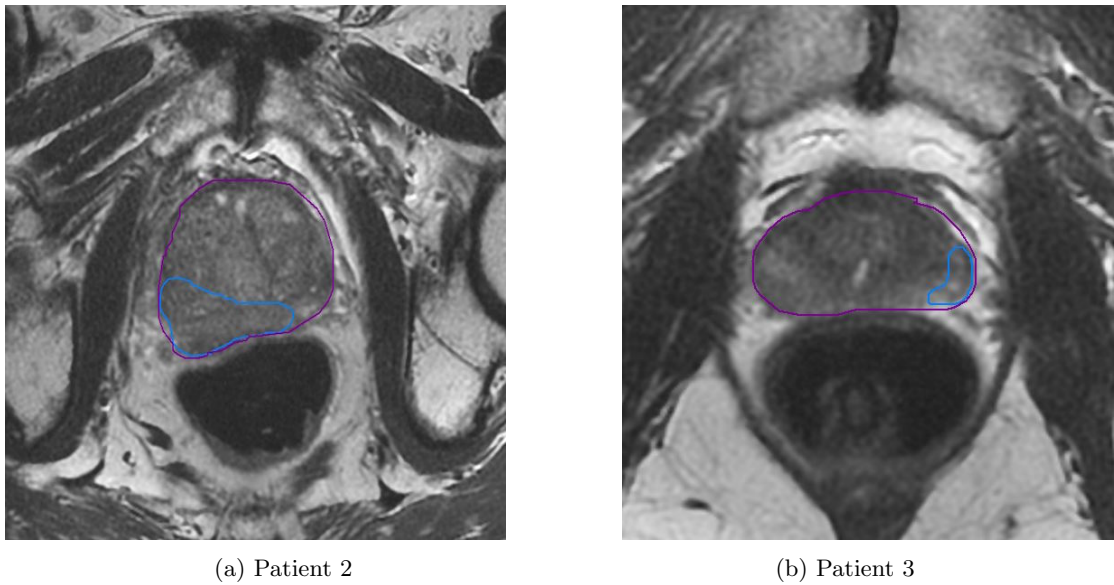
T2-weighted MRI scan of (a) patient 2 and (b) patient 3, including contours of $\text{Prostate}_{\text{MRI}}$ (magenta) and Boost_1 (light blue).
